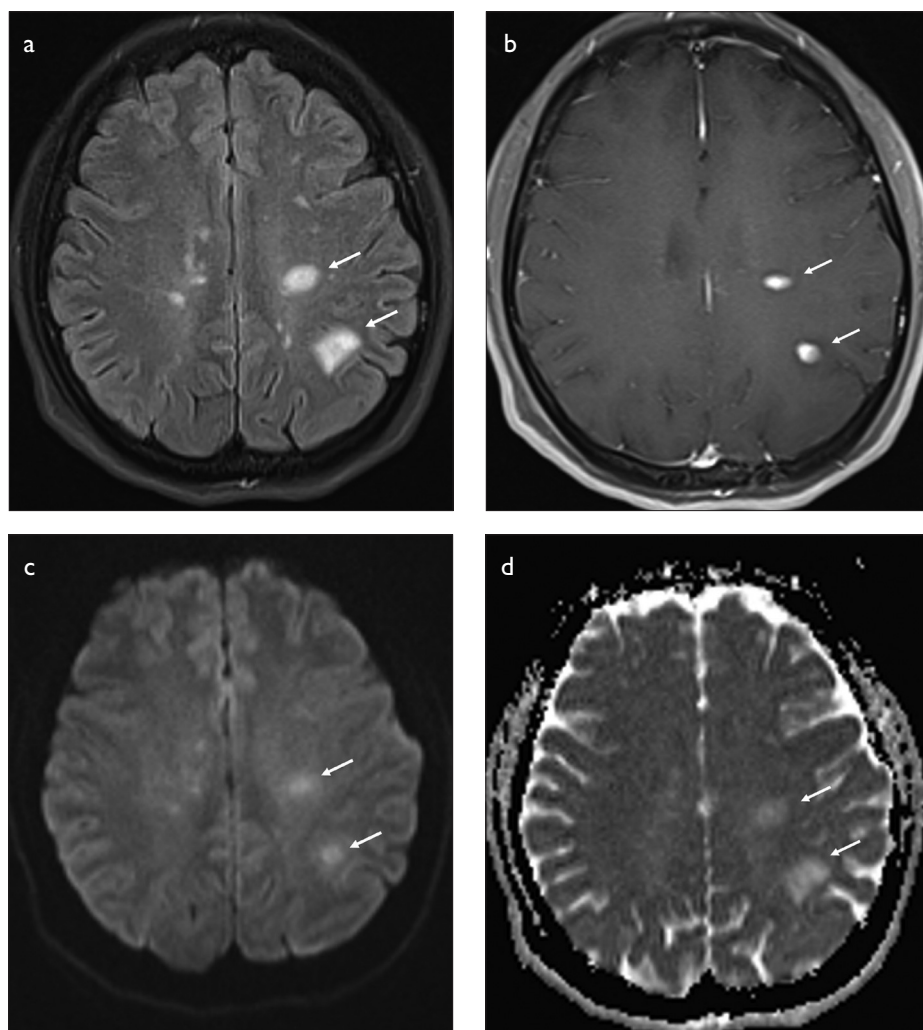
a-d. a) Axial plane FLAIR image of a patient with active MS lesions at the left centrum semiovale (arrows). b) Axial plane contrast enhanced image of a patient with active, enhancing MS lesions at the left centrum semiovale (arrows). c) Axial plane diffusion weighted image of a patient with active MS lesions at the left centrum semiovale. Lesions are hyperintense on diffusion weighted image (arrows). d) Axial plane ADC map of a patient with active MS lesions at the left centrum semiovale. Lesions show no diffusion restriction (arrows).
